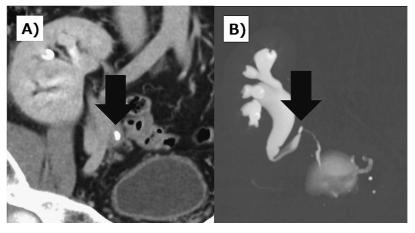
CT demonstrating a 6-mm calculus (arrows) at the ureteroureterostomy site.
